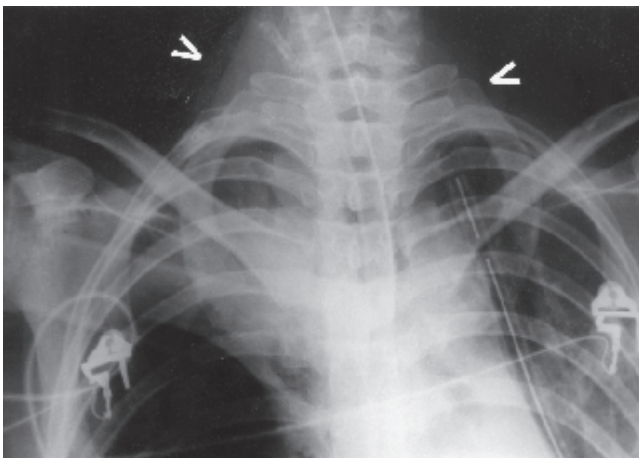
Radiograph of the chest demonstrating lung-re-inflation following the insertion of bilateral chest drains (the left drain is at the base of the pleural cavity and not visible on this view). Note the bilateral emphysema in the neck (arrows).
